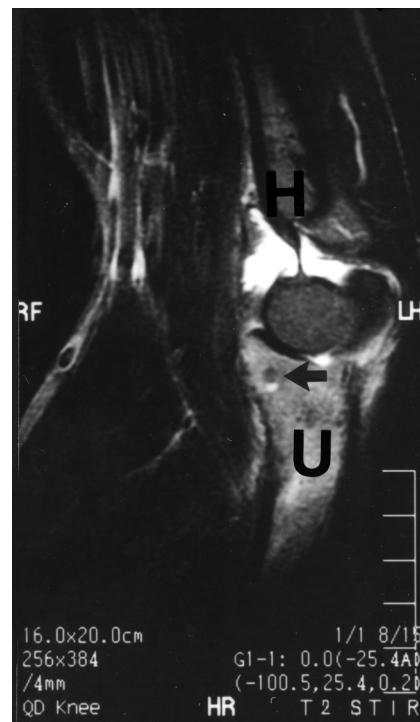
T2 weighted MRI (short inversion time recovery) of the left elbow (sagittal view). The tumor is located at the coronoid process (arrow). Marked edema was noted at the adjacent proximal ulna, with joint fluid collection, suggesting concomitant arthritis. U: ulna, H: humerus.
